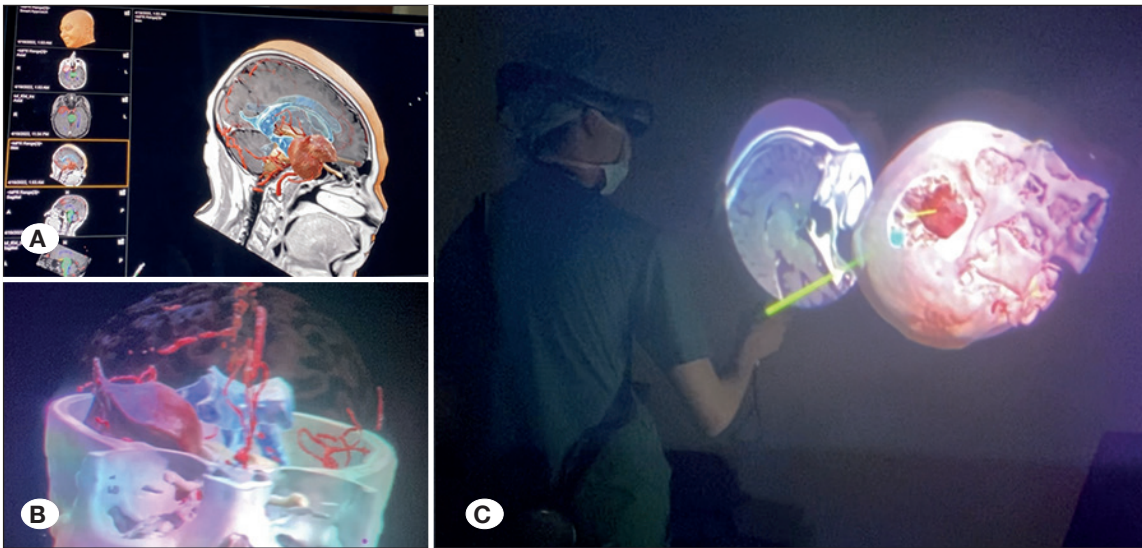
A) creation of the 3D holograms using thin-section cranial MRI scans. B) Determination of the lesion's location. C) Preoperative craniotomy plan. 3D: three dimensional; MRI: Magnetic resonance.
